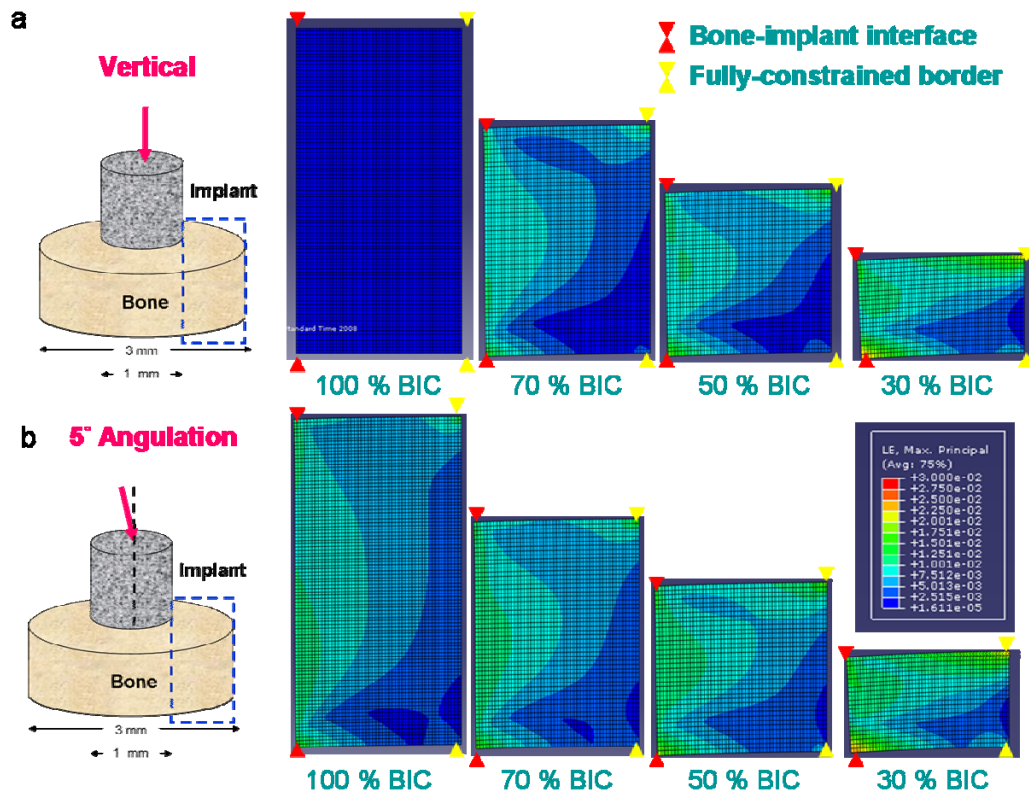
The strain distribution of implant-supporting tissue from different bone-implant contact (BIC) ratio and angulation of pushing-out force. The strain distribution of implant removal vertically (upper panel) and 5 degrees of deviation (lower panel) demonstrated that the strain increased with decreasing areas of contact, and the maximum strain occurred near the bottom of the interface. Within a 5 degree deviation of implant removal did not significantly result in radiographic detectable deformation.
